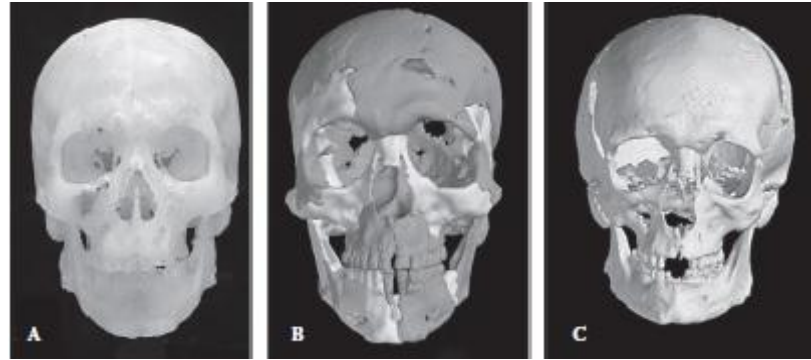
Replica skull (A) produced from (B) reassembled CT data or (C) laser scans²¹².
